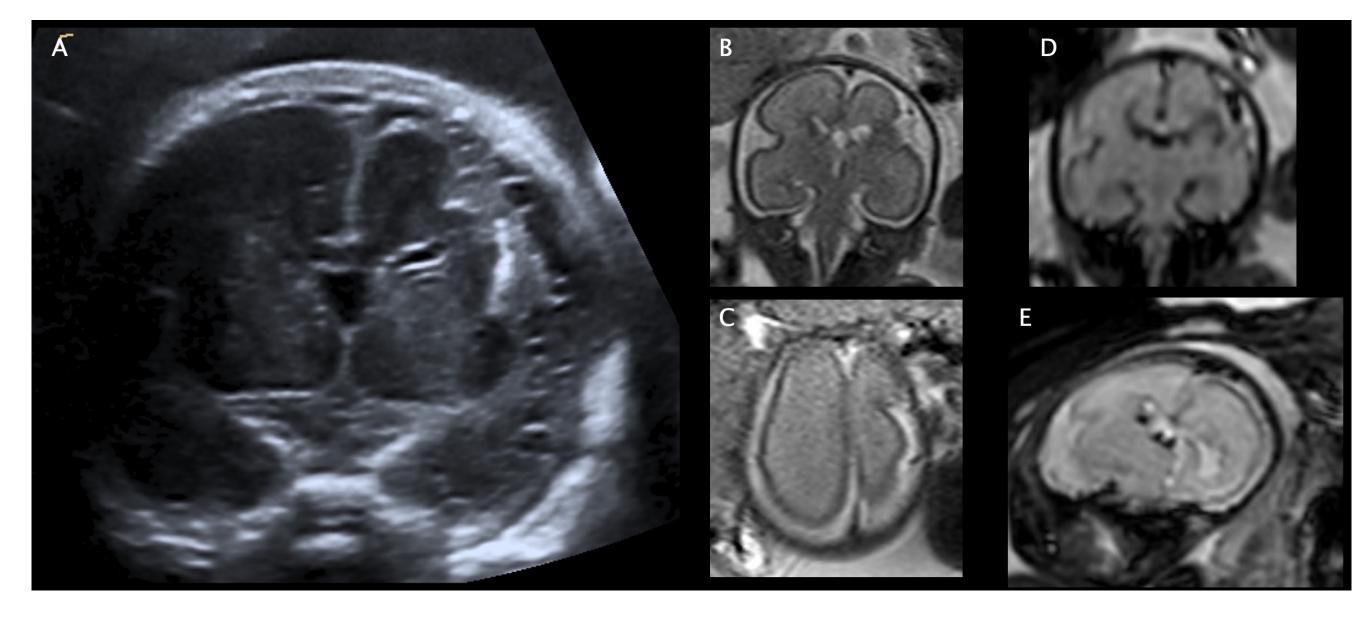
Follow up week 25+3; A) sonography compared to different sections and sequences of the MRI B)-E)
